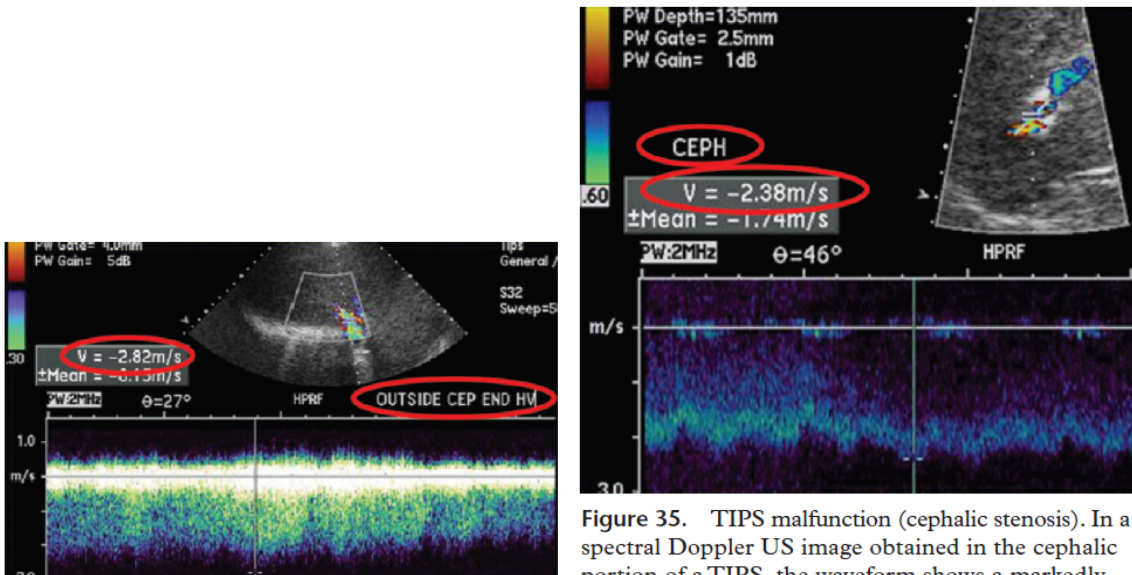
TIPS malfunction (hepatic vein stenosis). Spectral Doppler US image shows high-velocity flow (282 cm/sec), which is evidence of hepatic vein stenosis. Visually perceptible narrowing was also apparent in the color Doppler image.
